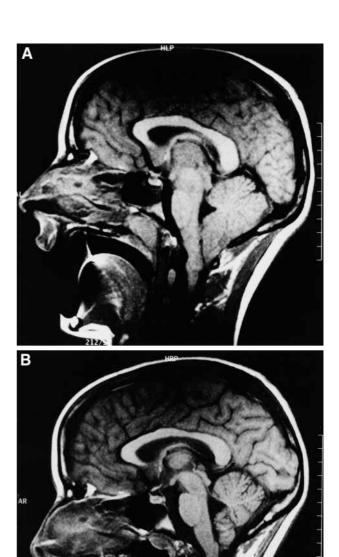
MRI brain scan of patient 4 (A) before start of the ICP-reducing therapy, showing a transtentorial herniation with protrusion of the cerebellum tonsils below the foramen magnum, and (B) 5 weeks later, showing a normal MRI scan.
